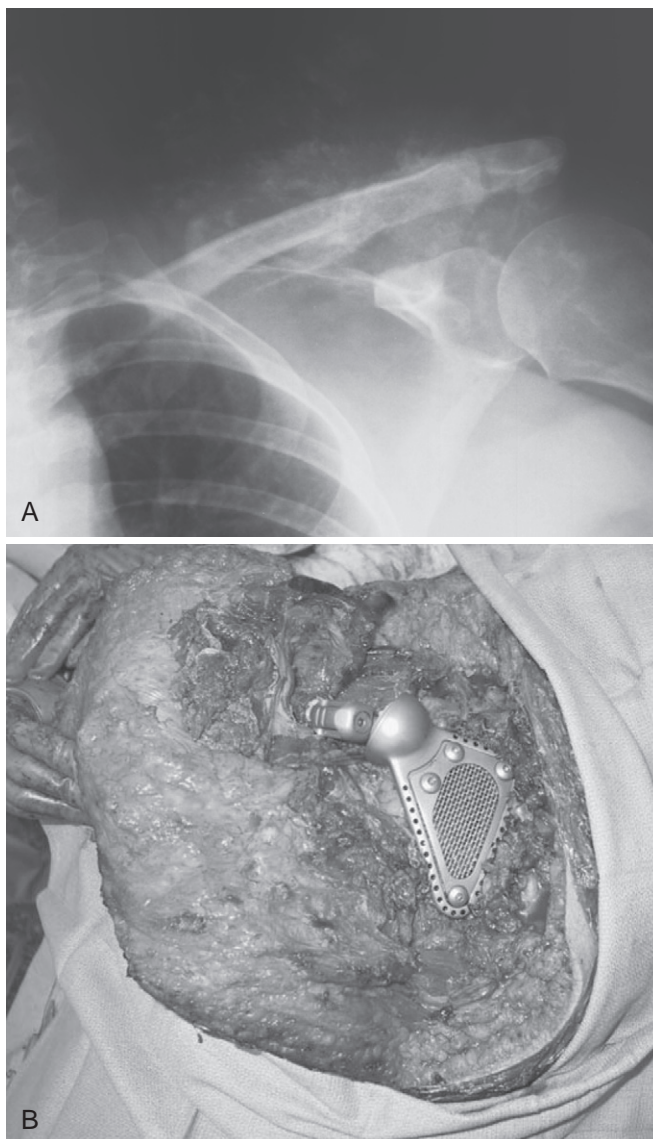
A, Osteogenic sarcoma in the left scapula of a female patient with Li-Fraumeni syndrome. This patient had a family history of osteogenic sarcoma in a first-degree relative. At the time of staging for the osteogenic sarcoma in the scapula, a lesion in the breast was discovered on computed tomography (CT) of the chest. This was subsequently found to be an adenocarcinoma. B, The patient underwent a scapular replacement. A latissimus dorsi flap was used for skin cover.
